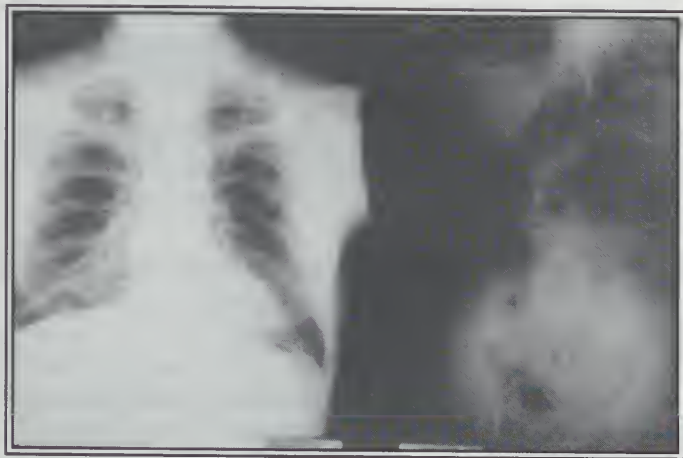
Standing chest & abdominal roentgenograms
